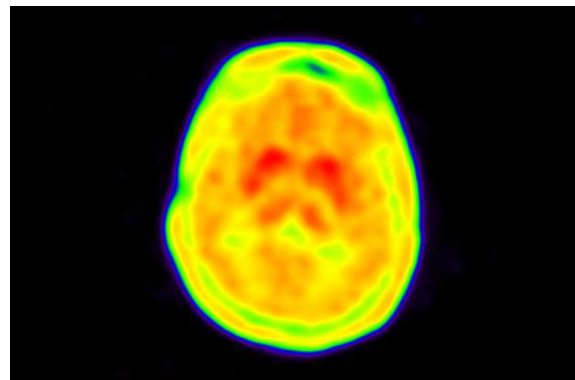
The example of PET/CT imaging after colours the image.
